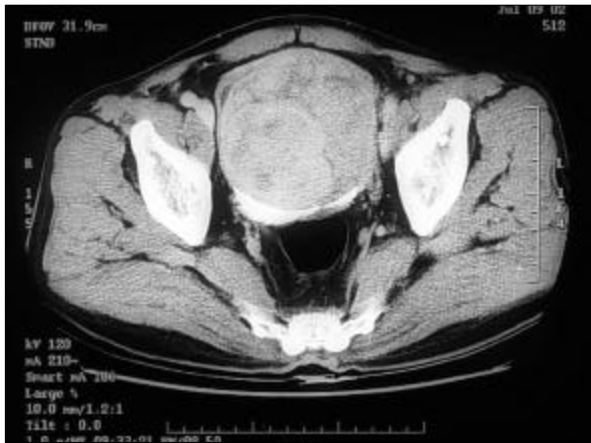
CT scan revealed a 12 cm sized huge mass with heterogeneous attenuation in the urinary bladder.
